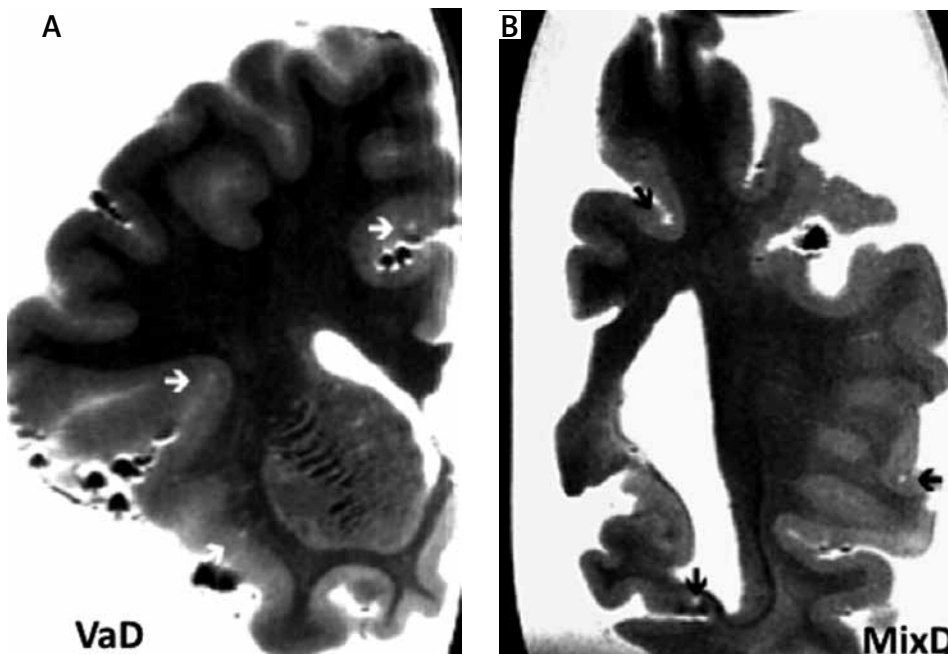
T2 MRI demonstrating the presence of cortical microinfarcts (arrows) on a coronal section of the frontal lobe in a patient with vascular dementia (A) and of the occipital lobe in a patient with mixed dementia (B).
